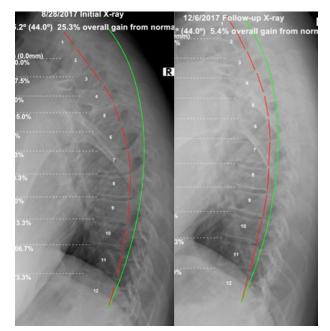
Lateral thoracic radiographs. Left: Initial (8/28/17); Right: Follow-up (12/6/17). Green line indicates normal thoracic kyphosis; red line highlights patient posterior vertebral body margins (CBP Seminars, Inc.).
